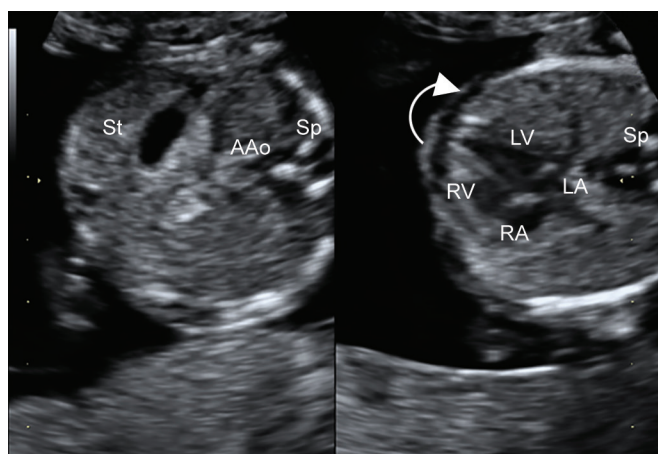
Early fetal echocardiography by 2D in a structurally normal heart. Situs visceral. Left: Fetal stomach, cross section of the abdominal aorta, spine and liver. Right: Four-chambers view. Heart axis pointing left, heart occupies one-third of the thorax, majority of heart in left chest
